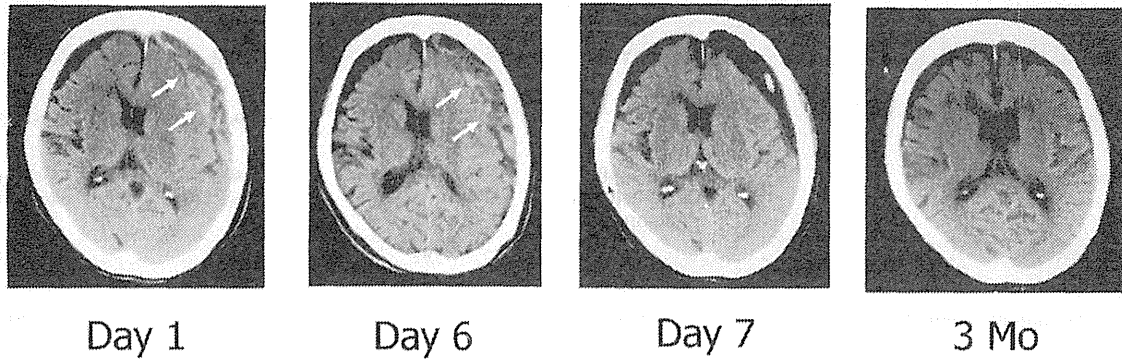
Head computed tomography of an 87-year-old woman (case 2) on days 1, 6, 7 and 3 months thereafter. The arrows show that subdural hematoma on day 1 has not expanded by day 6. The patient fully recovered at 3 months after burr-hole evacuation on day 7.
